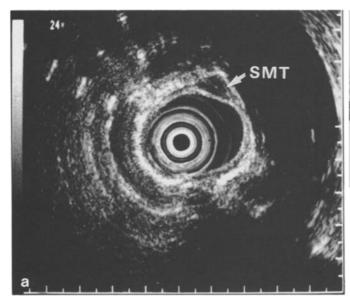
Endoscopic ultrasonographic findings of a cyst (arrow) of the esophagus
